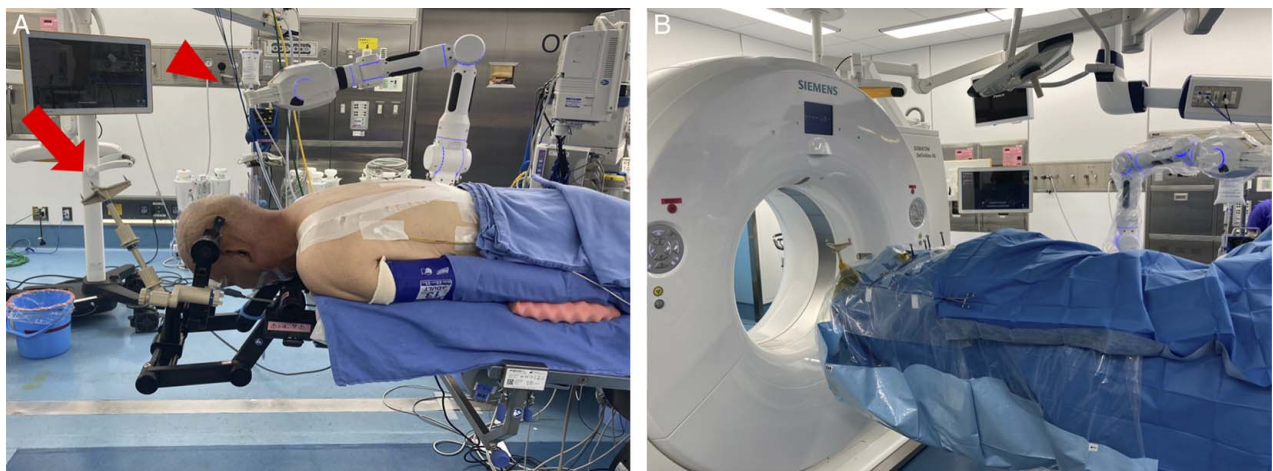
A, Preoperative positioning with the Cirq robotic system (arrowhead). The reference array was attached to the Mayfield holder (arrow). B, Intraoperative computed tomography image acquisition.
